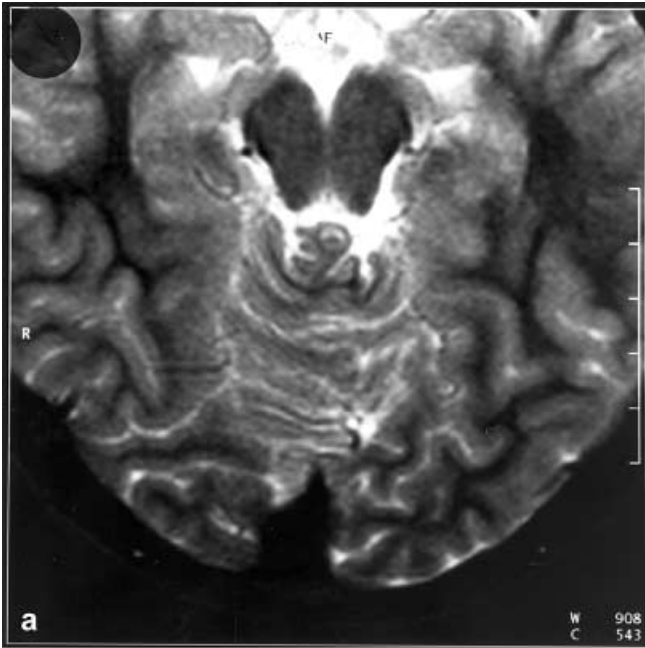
a, b. Coronal T2-weighted images showing two examples of abnormal fissuration and foliation of the anterior lobe of the vermis, extending to the posterior lobe. Note extension of the abnormalities into the hemispheres and reduced branching of white matter
